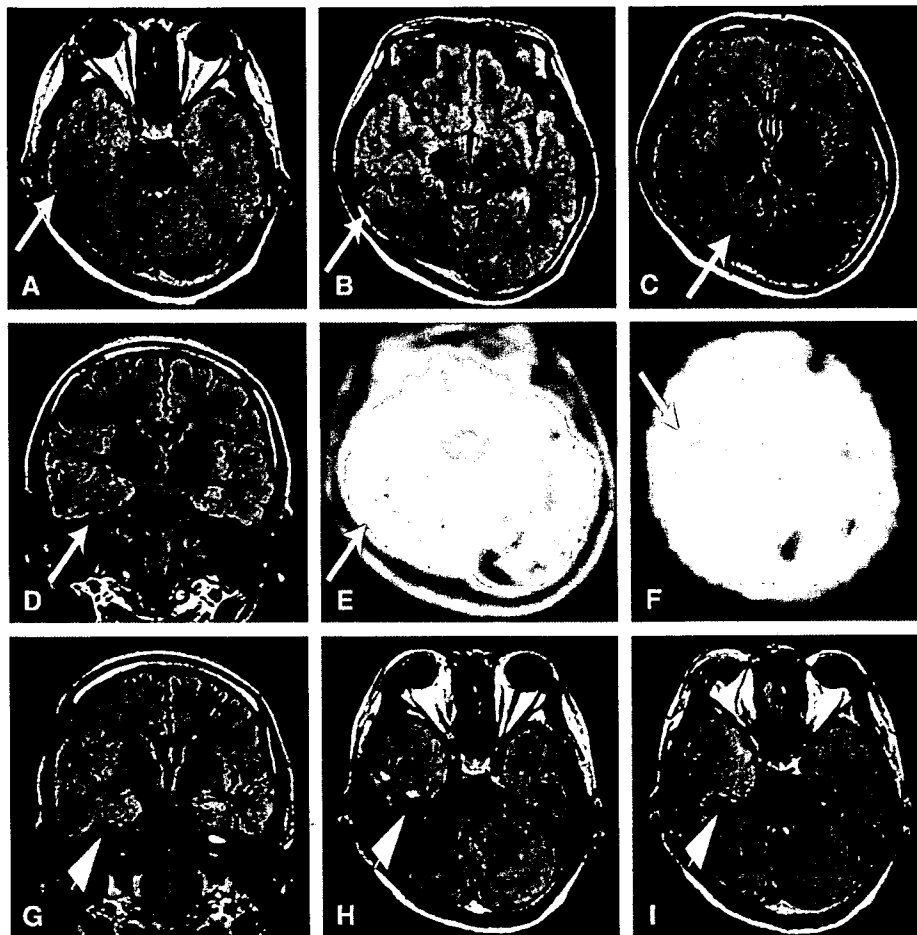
Preoperative brain MRI (A–D), interictal FDG-PET (E), ictal SPECT (F) and postoperative brain MRI (G–I). (A–D) Massive MCD including a schizencephaly and polymicrogyria in the right temporo-parieto-occipital area (arrows). (E) Heterogeneous regional glucose hypometabolism in the right temporo-occipital area. (F) Ictal SPECT showed an increased perfusion in that area. (G–I) Small area with the most active epileptogenicity was resected (arrowhead). The patient showed reduction of seizures (Engel's class IIA) in spite of a large residual lesion.
